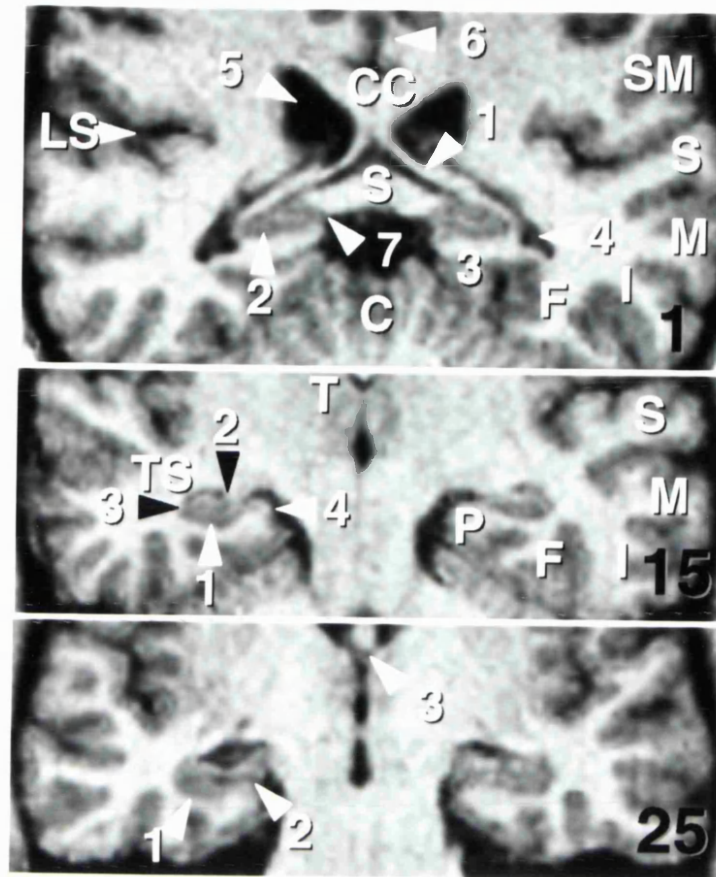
Hippocampal tail, body and head. MPRAGE images of a control subject were reformatted into 1 mm thick contiguous sections. The black numbers in the right lower corner are the section numbers. The MRI section in which the crus fornix is seen in its full profile is defined as the first section for hippocampal volumetry (see *hippocampal volumetry*, p 57). Section 15 and 25 are 15 and 25 mm more anteriorly than section 1. Section 1. The crus fornix is seen in its full profile (1). The hippocampal tail (2) is bordered laterally by the temporal horn of the lateral ventricle (4), caudally by the isthmus (3), medially by the splenium (S) of the corpus callosum (CC), and superiorly by the crus fornix (1). The gyrus of Andreas Retzius, fasciola cinerea and gyrus fasciolaris (7) are not visible on these MR images. Cingulate gyrus (6), atrium of lateral ventricle (5), supramarginal gyrus (SM), superior temporal gyrus (S), middle temporal gyrus (M), inferior temporal gyrus (I), fusiform gyrus (F), cerebellum (C), lateral sulcus (LS). Section 15. The hippocampal body (1) gives rise to the fimbria (2) and is bordered laterally by the temporal horn of the lateral ventricle (3) and medially by the ambient cistern (4). Temporal stem (TS), parahippocampal gyrus (P), thalamus (T). Other abbreviations see section 1. Section 25. In the posterior part of the hippocampal head (1), the intralimbic gyrus (2) can be seen. Body of fornix (3).
